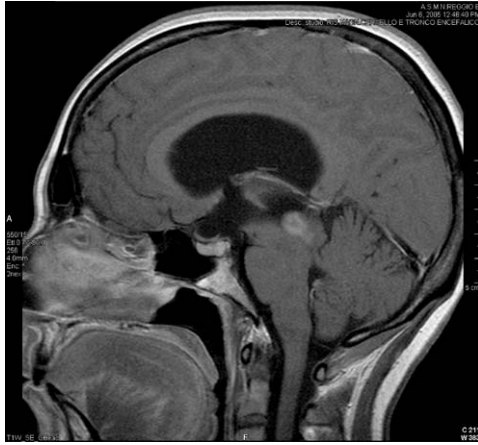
T1 sagittal contrasted MRI showing a 18 mm moderately enhancing lesion in the posterior third ventricle causing aqueduct stenosis and hydrocephalus.
